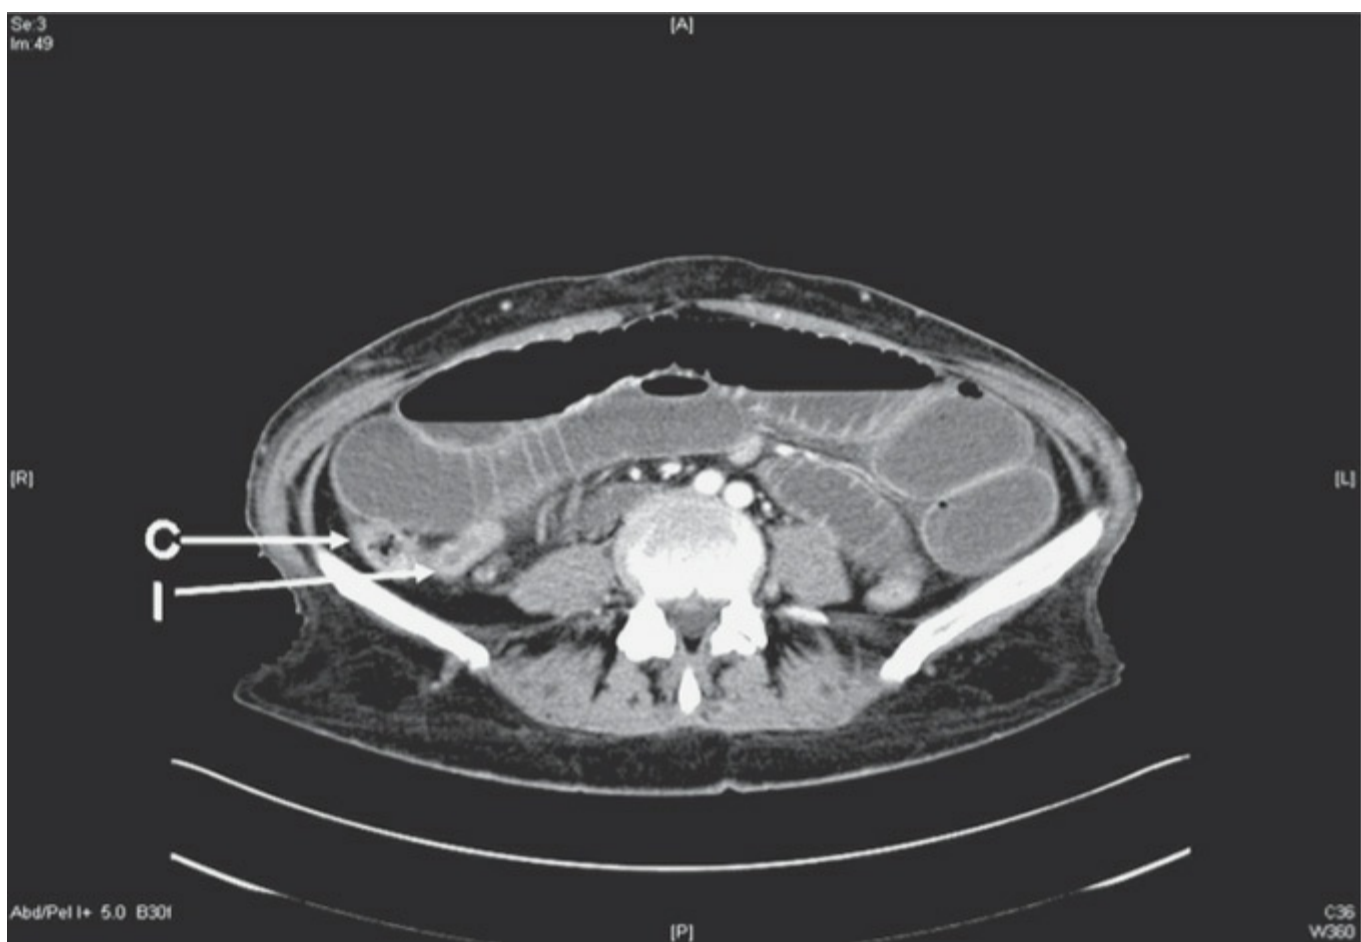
Small bowel obstruction. A computed tomography scan of a patient presenting with signs and symptoms of bowel obstruction. The image shows grossly dilated loops of small bowel, with decompressed terminal ileum (I) and ascending colon (C), suggesting a complete distal small bowel obstruction. (Reproduced, with permission, from Brunicaudi F, Andersen DK, Billiar TR, et al, eds. *Schwartz's Principles of Surgery*. 9th ed. New York: McGraw-Hill; 2010.)
